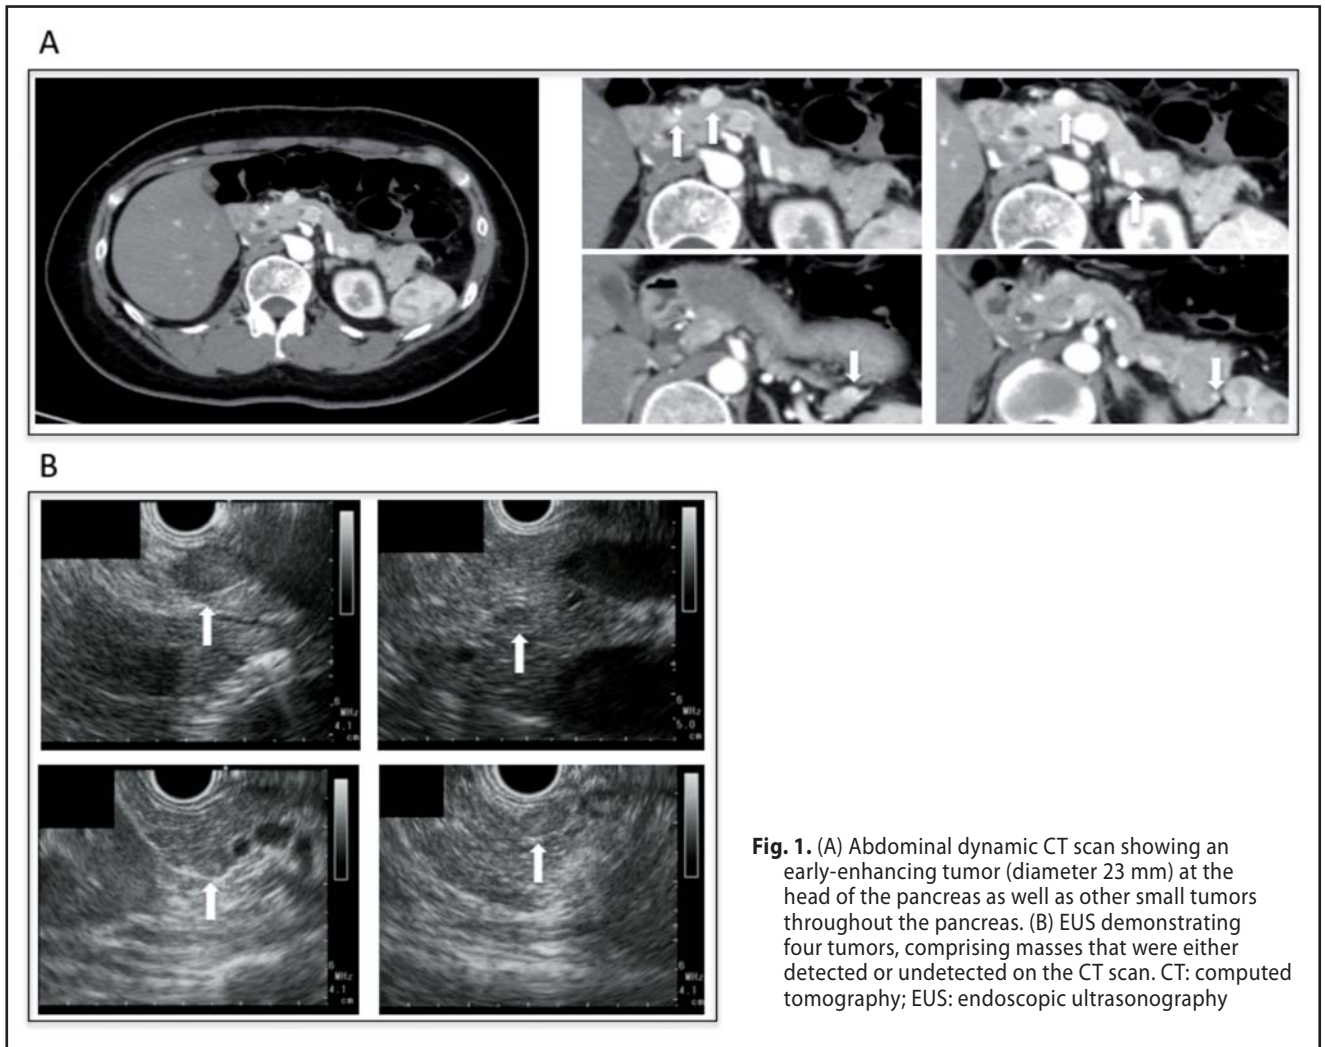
(A) Abdominal dynamic CT scan showing an early-enhancing tumor (diameter 23 mm) at the head of the pancreas as well as other small tumors throughout the pancreas. (B) EUS demonstrating four tumors, comprising masses that were either detected or undetected on the CT scan. CT: computed tomography; EUS: endoscopic ultrasonography
